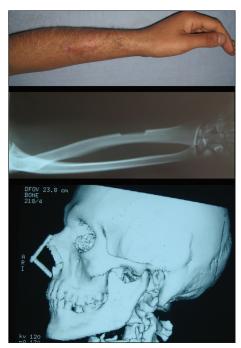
Late view of radial bone graft donor site (above), radiological appearance of radial bone graft donor site (center), three-dimensional CT imaging of L-strut bone graft (below).
